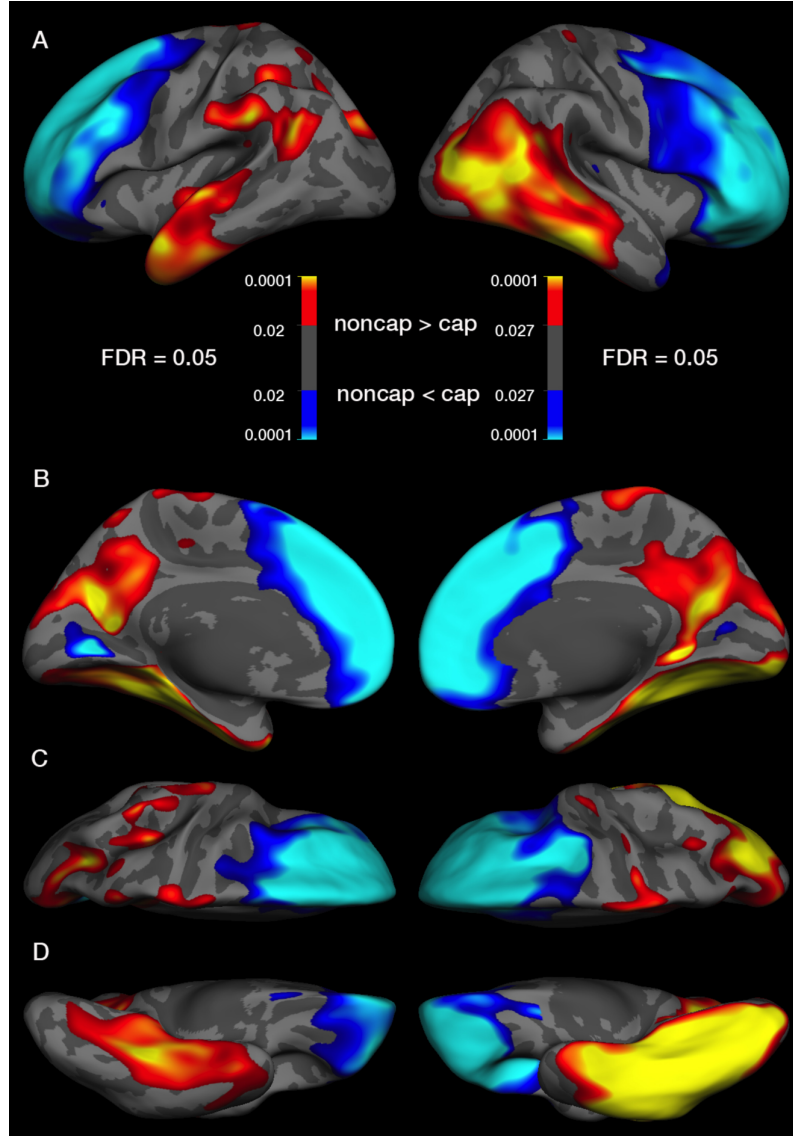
The influence of the high-density EEG net on cortical thickness measurement derived from surface-based morphometry of T1-weighted images shown on A) lateral, B) medial, C) superior, and D) inferior view of the left (left column) and right (right column) hemisphere. Cortical thickness is increased over frontal cortical areas (blue) and significantly decreased over the temporal lobe (yellow-red) when subjects wear the EEG cap (paired t -test, $FDR = 0.05$, false discovery rate corrected). The color bar represents FDR-corrected p-values.
